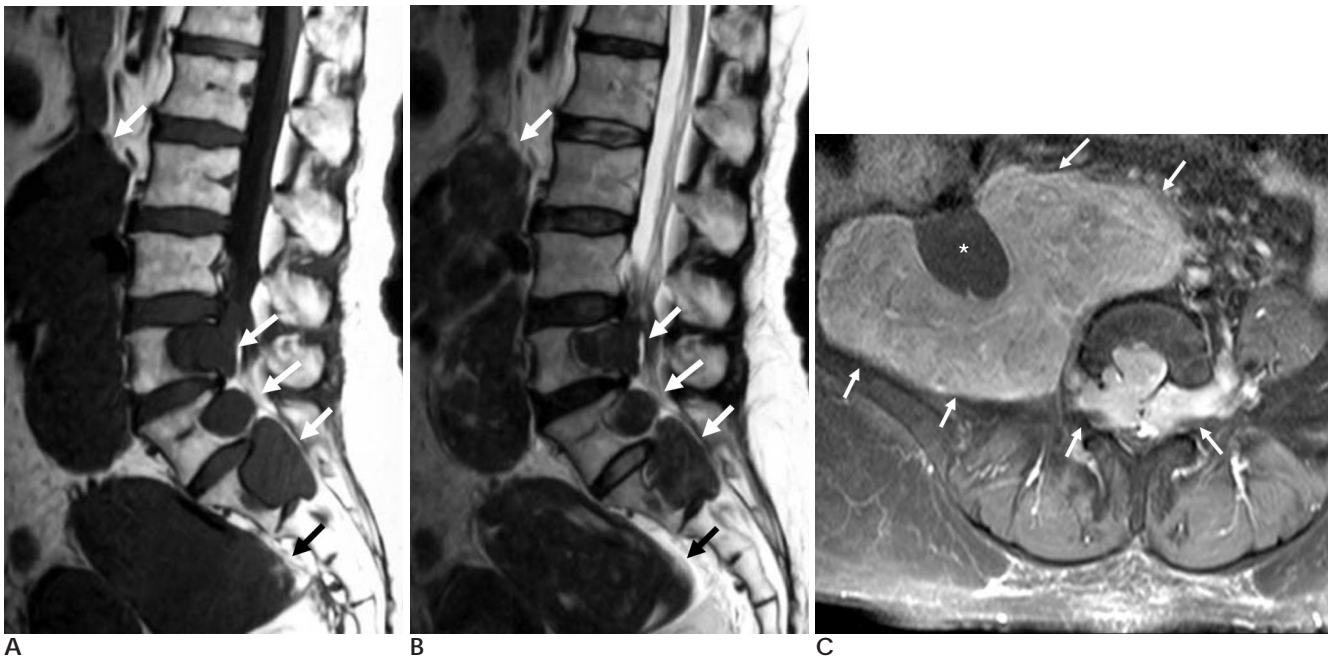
A. The sagittal T1-weighted MR image demonstrates a soft tissue mass in the spinal canal from the L5 to S2 levels and in the prevertebral space (arrows).
